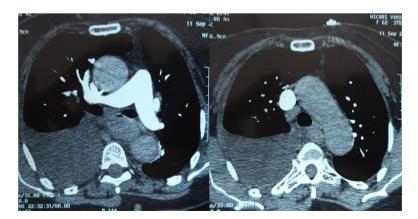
Computed tomography of chest showed a large lymphadenopathy in mediastinum.
